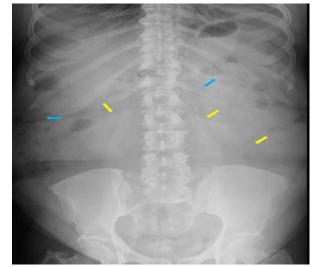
Abdominal radiograph showing a large soft tissue shadow occupying most of the pelvi-abdominal region (Yellow arrows) with displaced bowel loops peripherally (Blue arrows).
